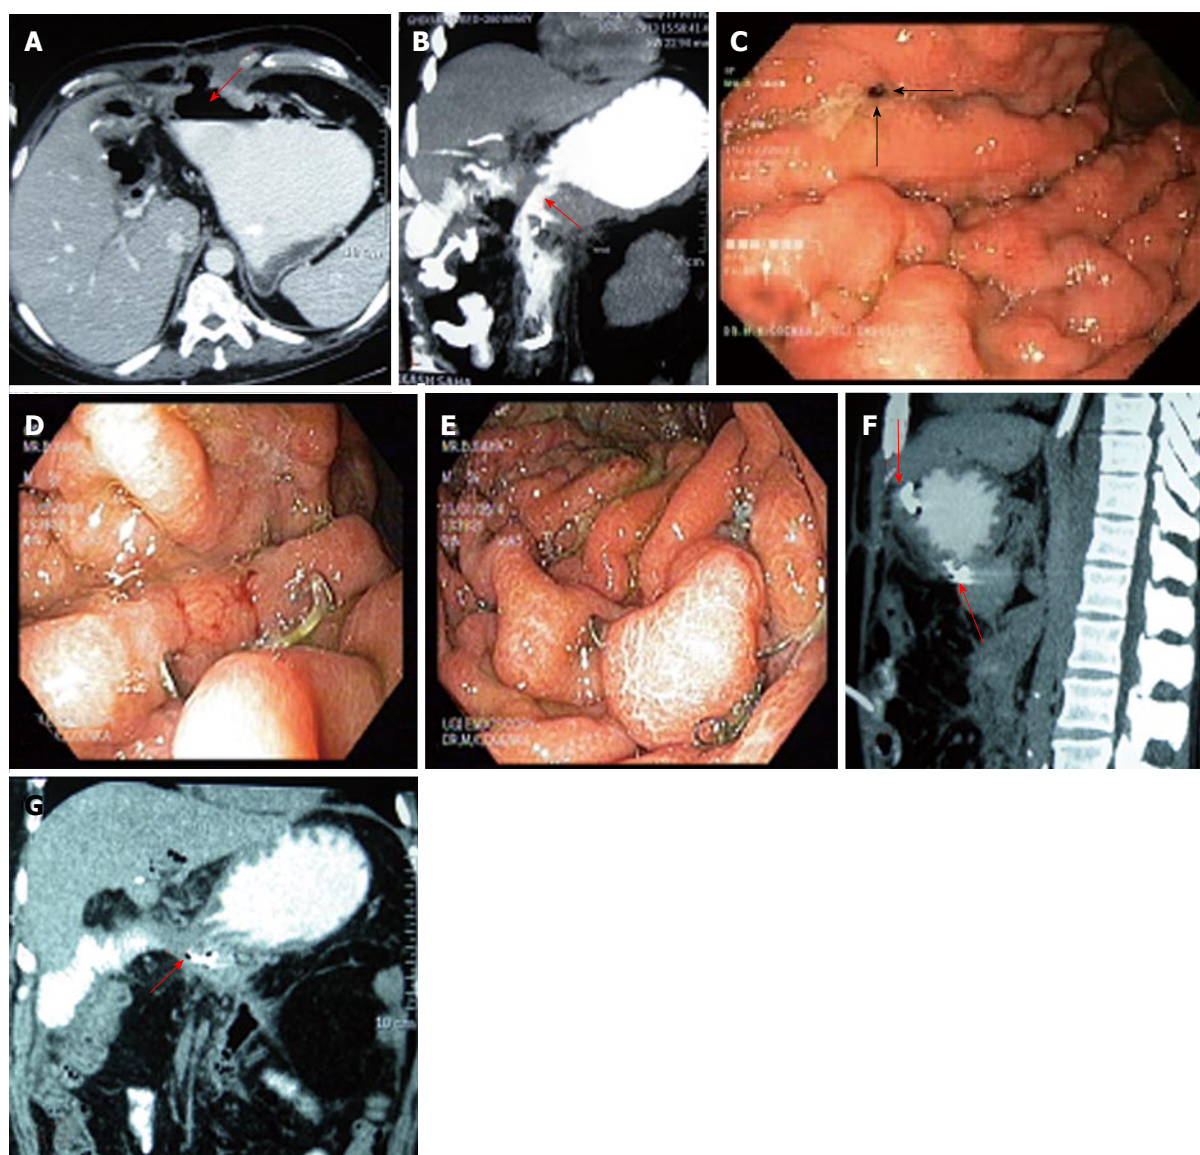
Dual gastric leak following Whipple's Surgery treated by over the scope clips. A and B: Anterior and posterior defects (arrows); C: Endoscopic view showing leak on anterior gastric wall (arrows); D and E: The OTS clips placed on anterior and posterior defects respectively; F and G: Follow-up CT scan showing the clips (arrows) with demonstration of closure of leaks. OTS: Over the scope.
